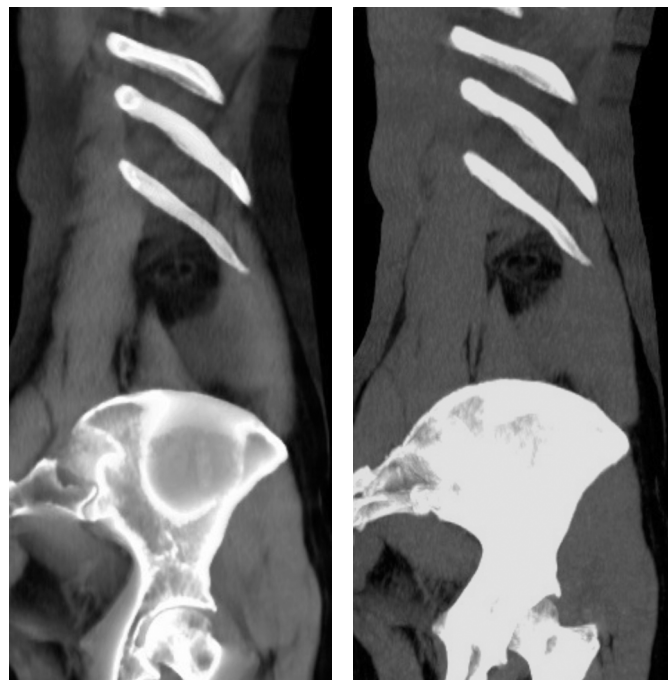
CT scan: sagittal views showing the presence of the hernia below the twelfth left rib.
